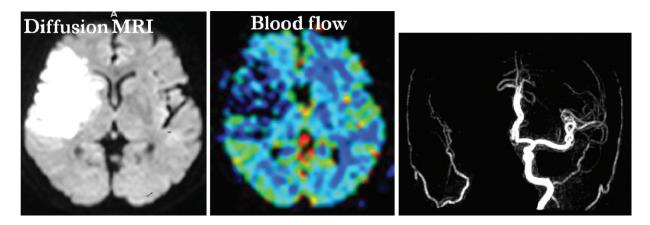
Acute infarction due to occlusion of right internal carotid artery showing lesion on DWI corresponding to perfusion MRI (blood flow) or "diffusion/perfusion match". It means totally infarct without penumbra of the ischemic area and no advantage to apply thrombolytic agent.
